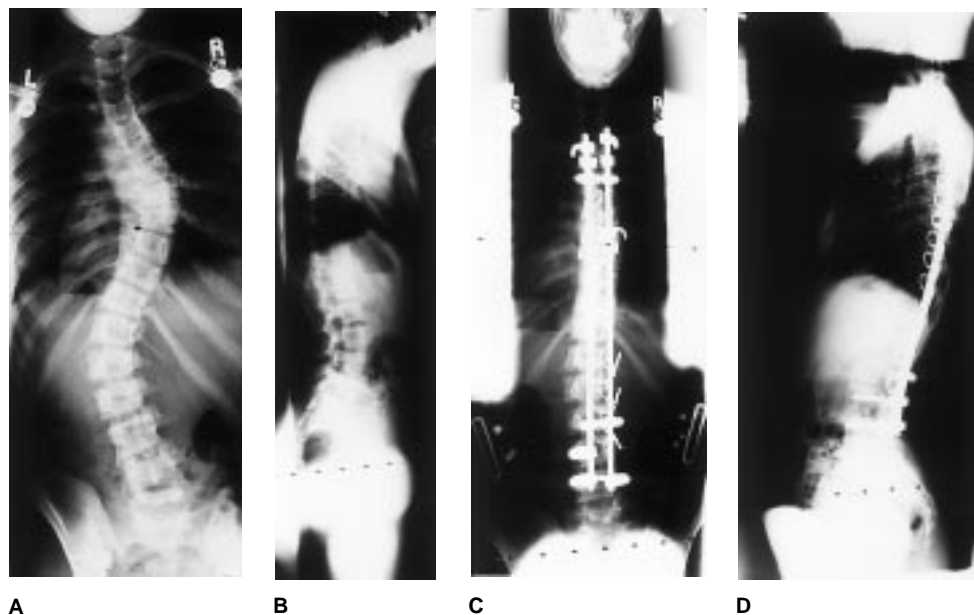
A and B, Preoperative radiographs of a girl aged 12 years 10 months with a 53-degree right thoracic curve and a 52-degree left lumbar curve. C and D, Postoperative radiographs of same patient at 13 years show a 20-degree right thoracic curve and a 13-degree left lumbar curve after posterior spinal fusion performed with use of Isola instrumentation and lumbar pedicle screws. (Courtesy of Michael F. Schafer, MD, Chicago.)
